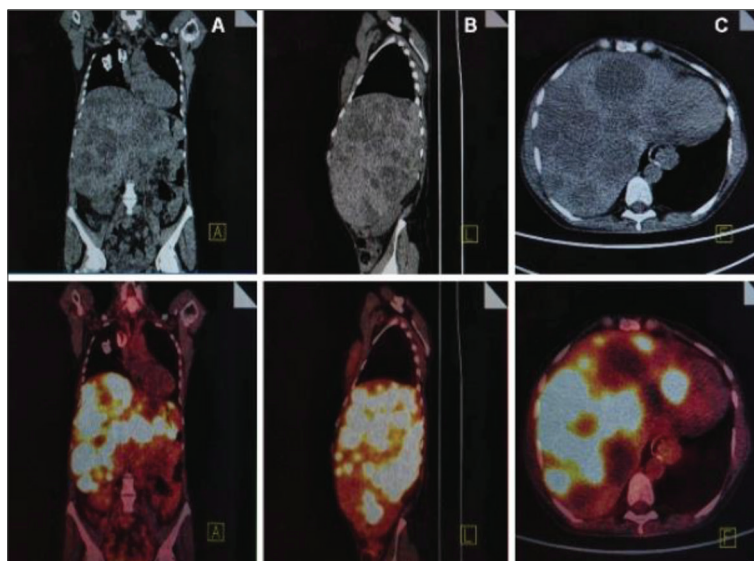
A – Coronal, B – Sagittal, C – Axial CT, fused PET/CT images of multiple single and confluent hypodense lesions with intense uptake of 18F-FDG; lesions without any uptake of 18F-FDG show areas of necrosis in the hepatic superscan image
